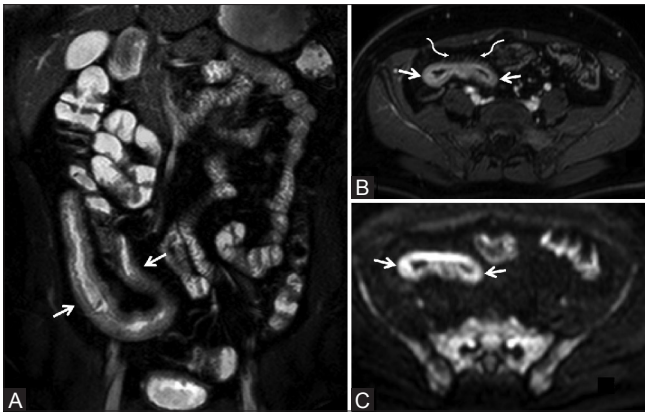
(A-C): Magnetic resonance enterography showing features of active inflammation in Crohn's disease. Hyperintense signal of thickened bowel wall on T2-weighted images (arrows in A); bowel wall stratification and mucosal enhancement (straight arrows in B) and prominent mesenteric vascularity (curved arrows in B) on post contrast T1-weighted images; restriction of diffusion on diffusion weighted images (arrows in C)
